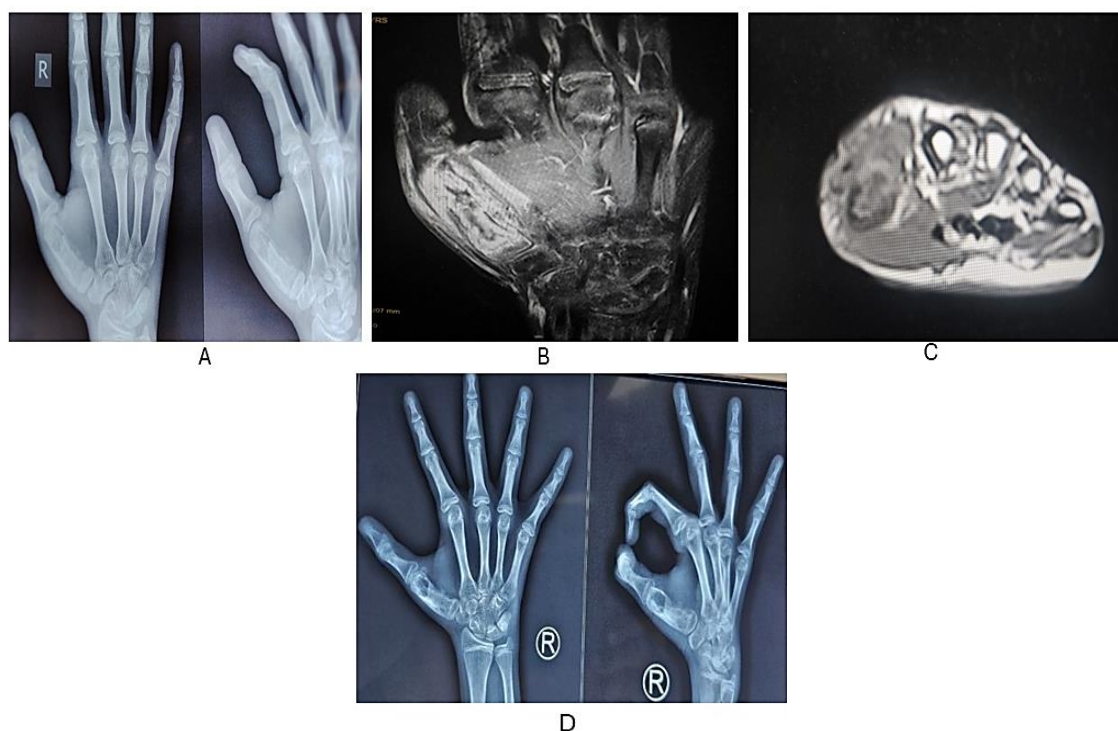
A) Anteroposterior (AP) and oblique views of hand showing osteolytic lesion involving 1st metacarpal with lamellated periosteal reaction; B and C) Magnetic resonance imaging (MRI) in the coronal and axial planes showing osteolytic lesion involving 1st metacarpal and extensive soft tissue involvement; D) AP and oblique views of hand showing healed lesion of 1st metacarpal at final follow-up
